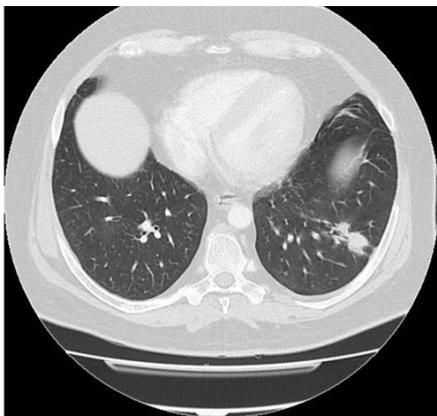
Chest CT scan 3 months after initiation of isavuconazole. Image courtesy of Martin Hoeningl, MD.
